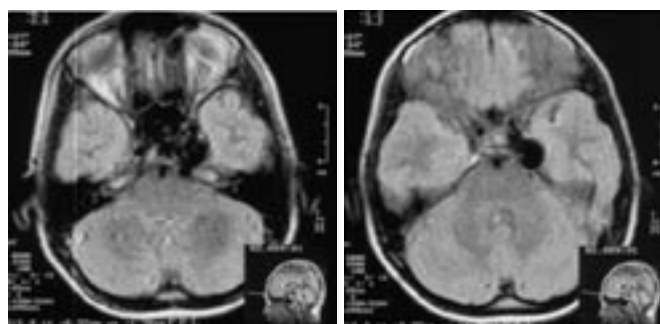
CT scan reveals a round low-attenuated lesion in the left cavernous sinus compatible with aneurysm.
